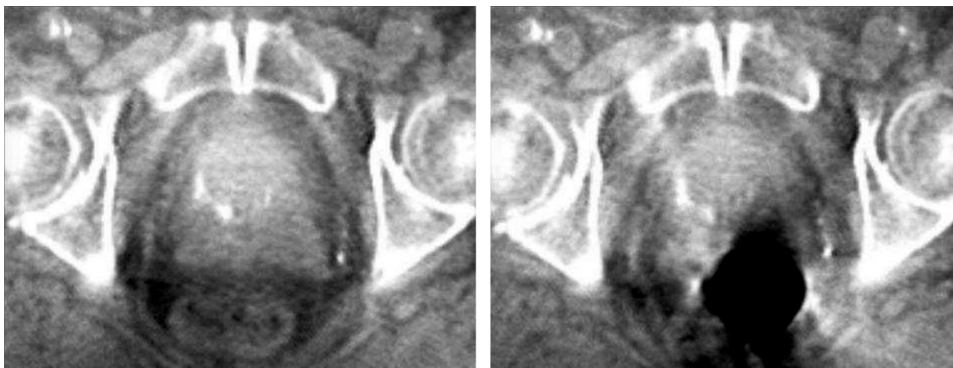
(Left) Cone-beam computed tomography scan registered using automatic procedure. (Right) Cone-beam computed tomography scan that could not be used for adaptive radiotherapy procedure because of moving gas.
